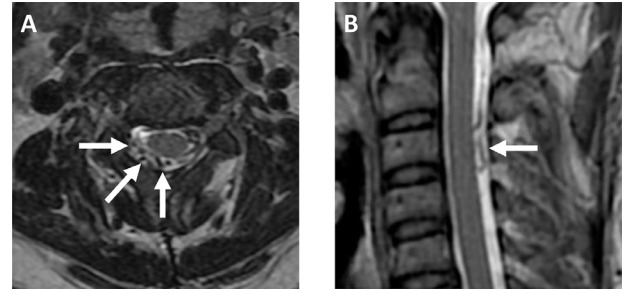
(A, B) Axial and sagittal T2 weighted magnetic resonance imaging serpiginous flow voids at the right dorsal aspect of dorsal thecal sac at the level of C2-C3.
